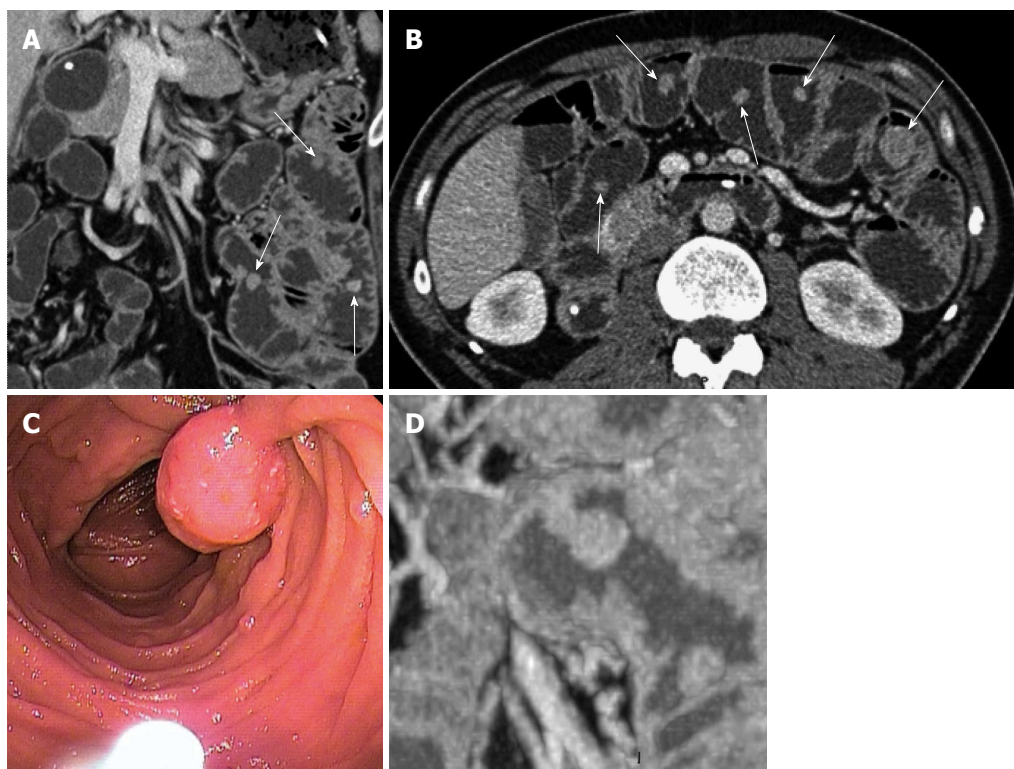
Polyp in a 44-year-old male with a known peutz-Jeghers syndrome. A: Coronal and B: an axial Multidetector computed tomography (MDCT) enteroclysis images reveals multiple, regular polyps with various sizes and shapes (arrows); C: The endoscopic view shows a pediculate polyp; D: A coronal MIP reformat shows the typical pediculate peutz-Jeghers syndrome (PJS) polyp aspect.
